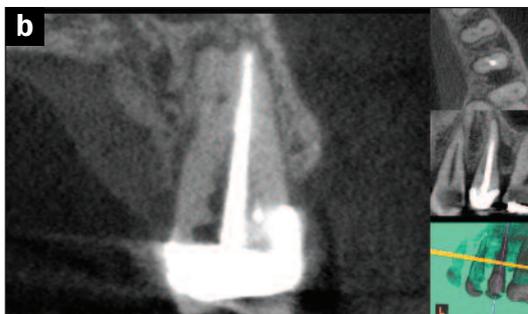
CBCT: Note the apical split of the main canal into 2 root tips. Also note the lateral canal feeding the lateral lesion.
